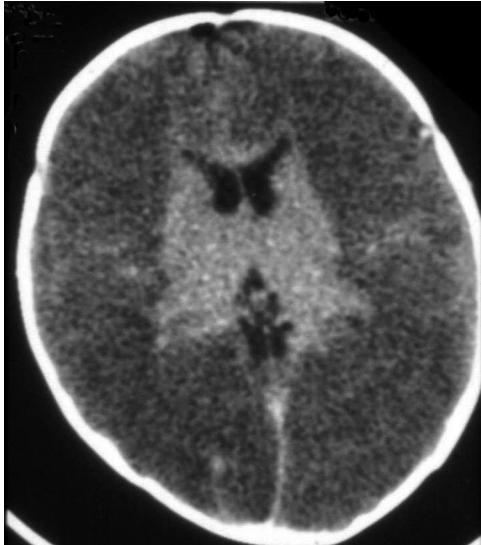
■ Global anoxic injury. Axial computed tomography scan of a child following cardiac arrest. There is diffuse low density in cerebral hemispheres and compression of ventricles and sulci, reflecting increased water accumulation (edema) and resultant mass effect. Basal ganglia and thalami appear bright.
